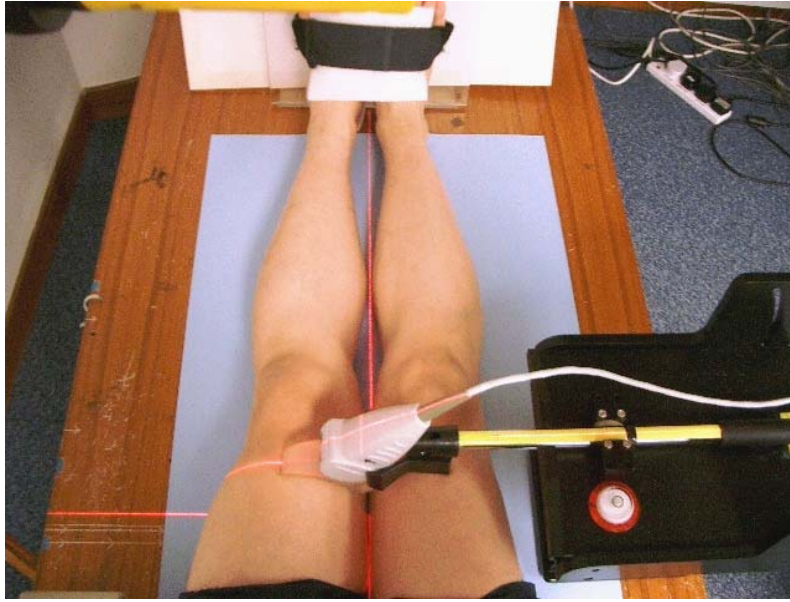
Setting of ultrasound scanning for VMO. A laser pointer projected a cross mark at the suprapatellar level and the distance between the sole of feet and the suprapatellar level was used to standardize repeatable positioning for the ultrasound scanning of the VMO.
